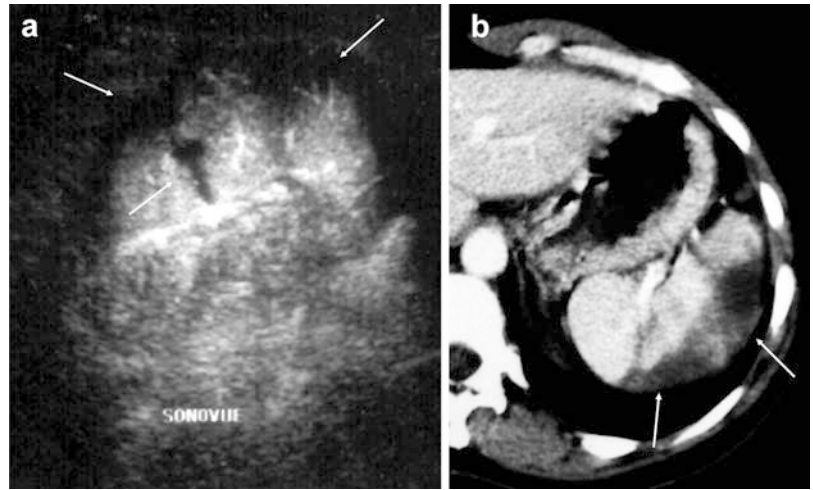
Splenic infected hematoma. Large, hypoechoic, inhomogeneous collection (*arrows*) is visible on contrast-enhanced US scan (a). Unenhanced CT scan (b) confirms diagnosis (*arrows*)
